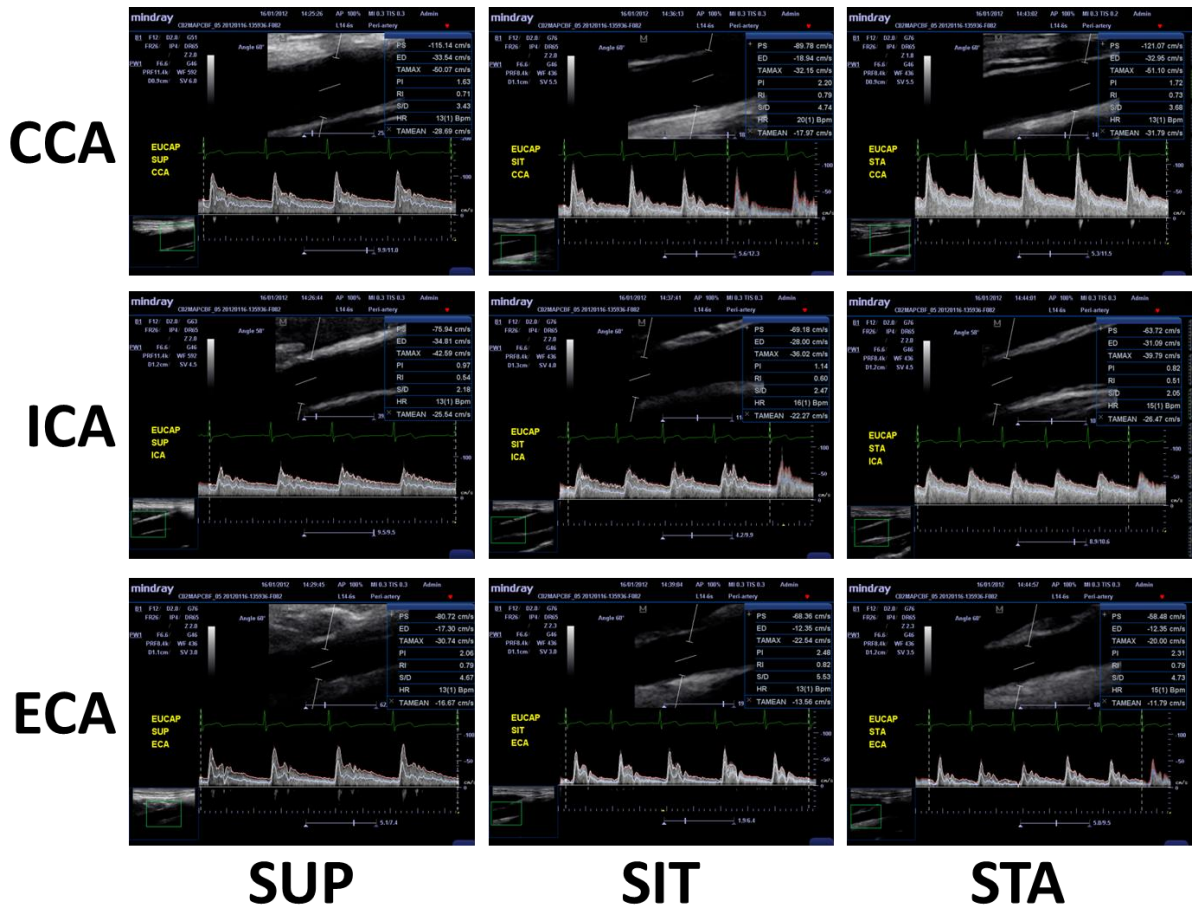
Representative ultrasound image captures of carotid artery in supine lying, sitting and standing.
